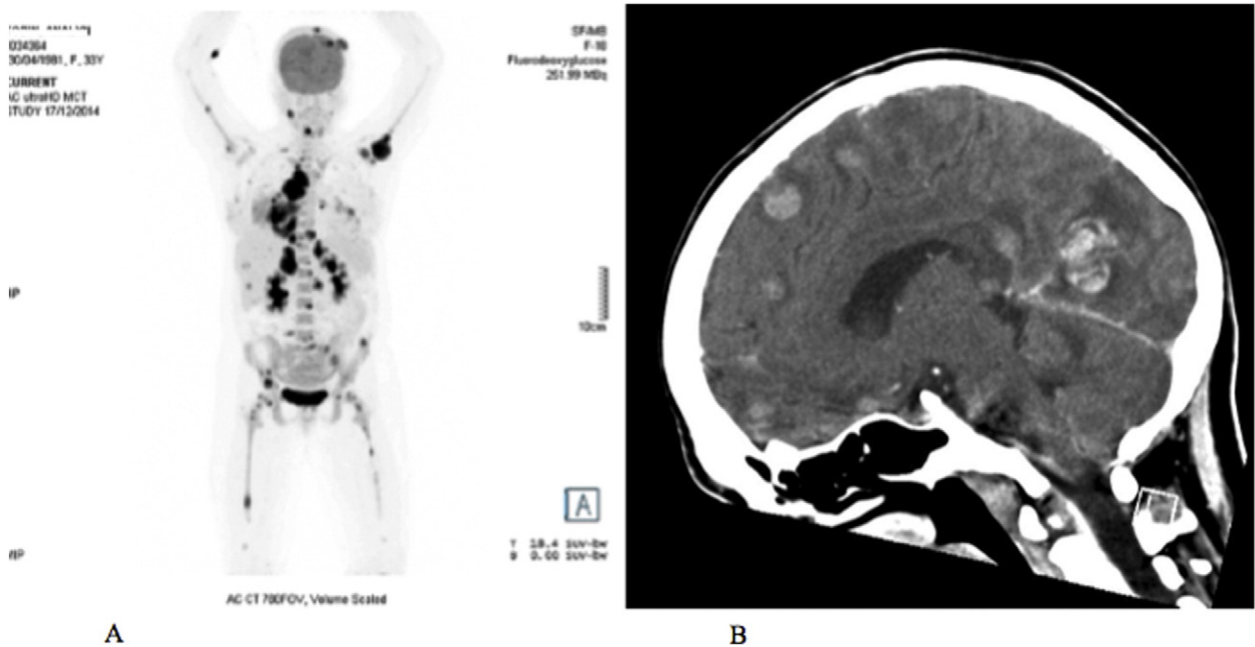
A: PET Scan: widespread FDG avidity consistent with pulmonary, pericardial, mediastinal nodal, cerebral, hepatic, adrenal, bony, breast and subcutaneous metastasis B: CT Brain: multiple haemorrhagic supra and infra-tentorial brain metastasis.
